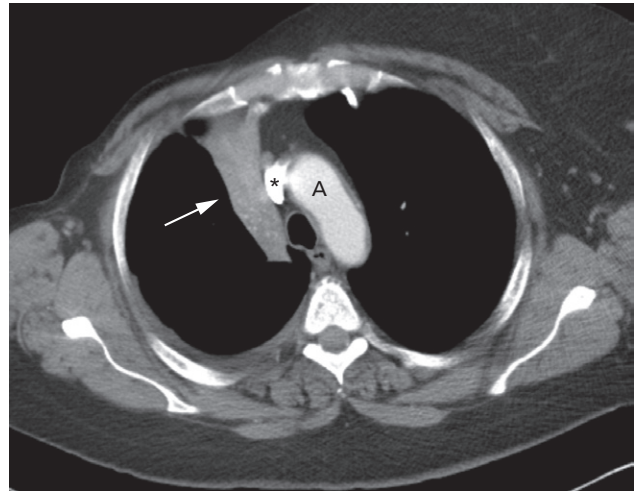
CT of a severely collapsed right upper lobe. Note the smooth lateral border of the collapsed lobe formed by the displaced oblique (major) fissure (arrow). The scan shows compensatory overexpansion of the left upper lobe, which has crossed the midline anterior to the aortic arch (A). The superior vena cava is highlighted with an asterisk.
